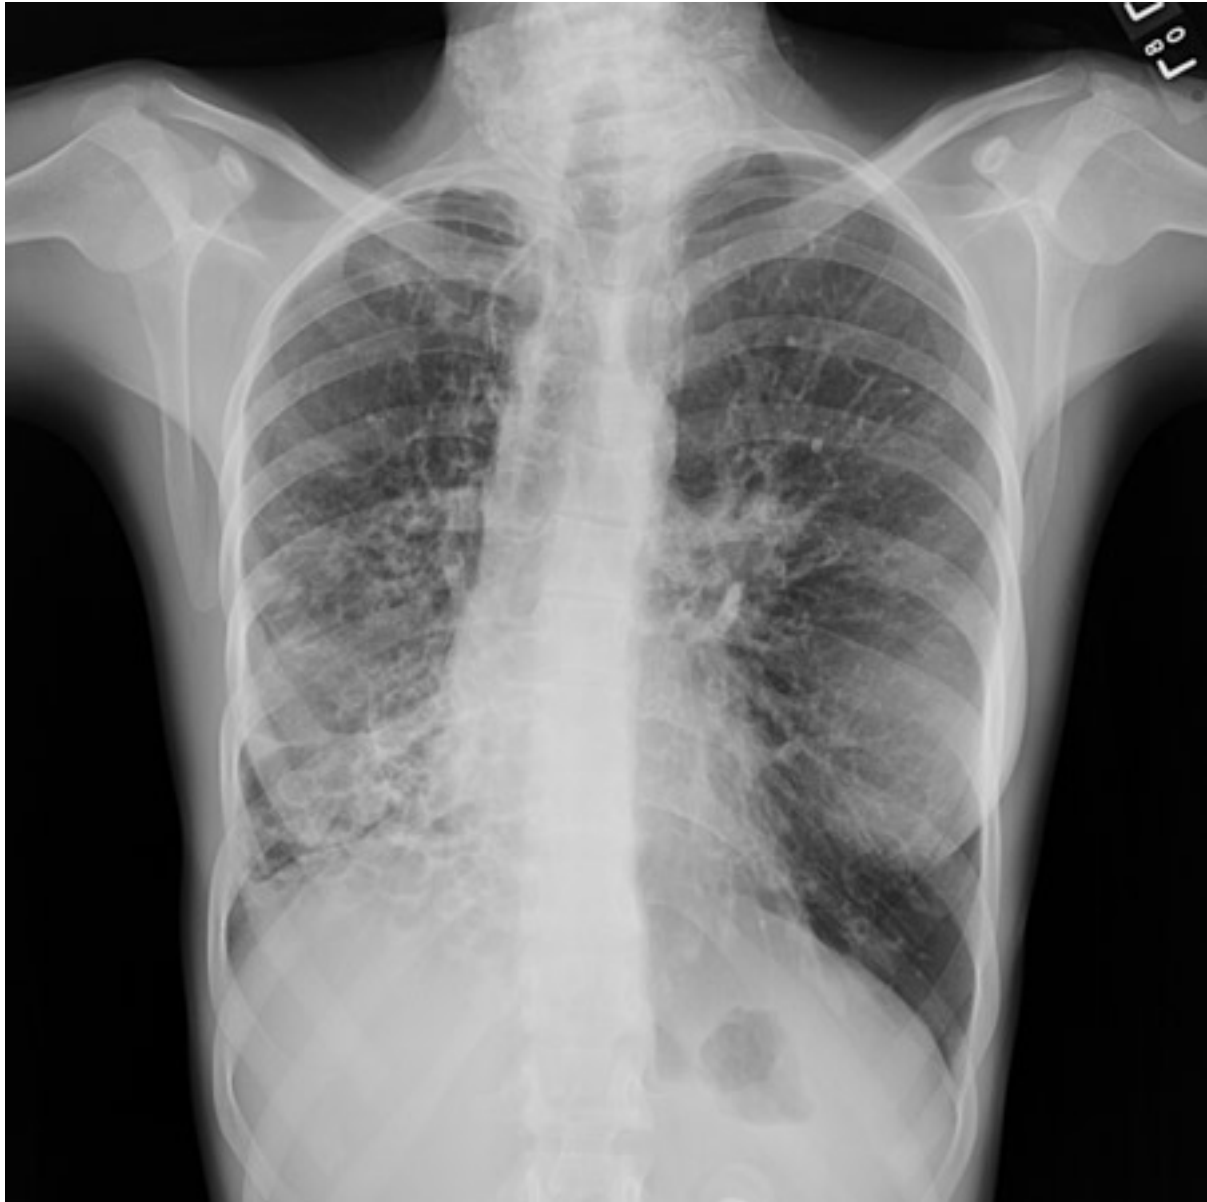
Chest x-ray showing pulmonary tuberculosis with cavitation*
